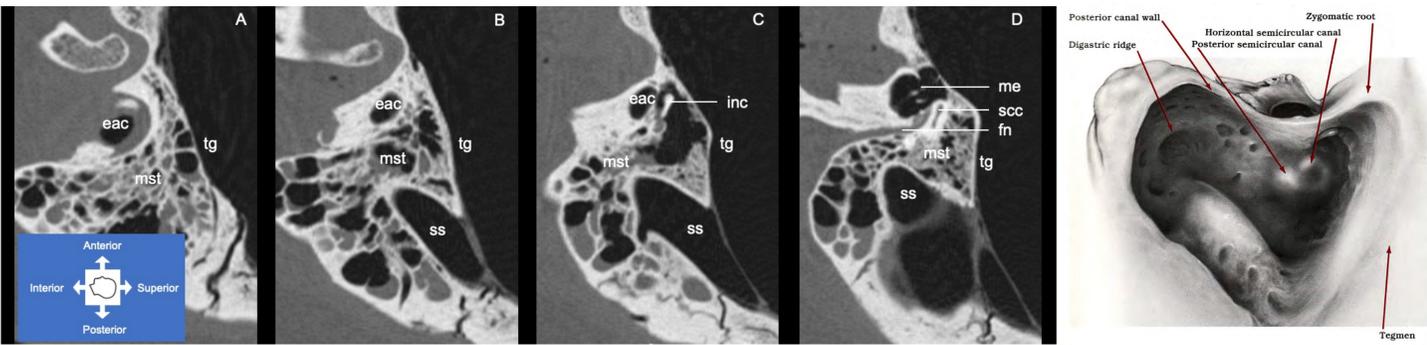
Sagittal CT series from lateral to medial of a left temporal bone. 90-degree clockwise rotation of the CT images to mimic a surgical orientation.
